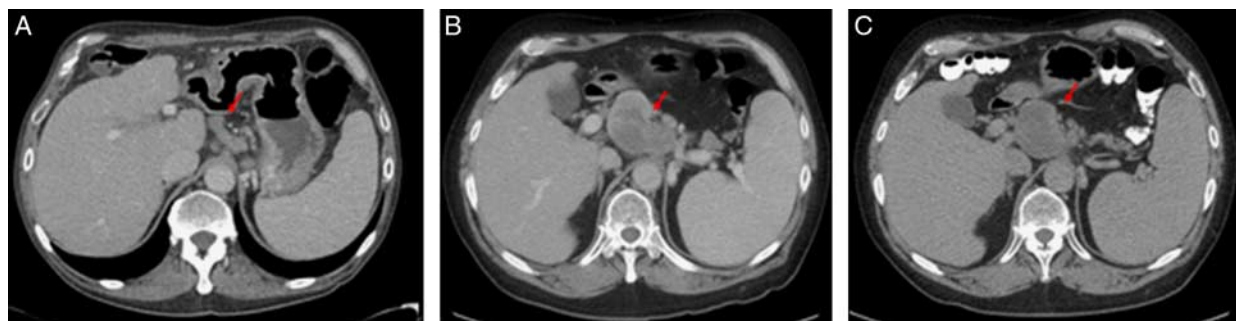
Case 3 CT scans over treatment course. A, Axial CT image demonstrates mildly enlarge gastrohepatic lymph node (red arrow) measuring 13 mm short axis on October 11, 2020, when the patient went to hospice. B, Axial CT demonstrated a significant increase in severity of lymphadenopathy after treatment lapse with the gastrohepatic lymph node short axis at 45 mm, with central hypoattenuation, possibly representing necrosis (red arrow). C, After 4 months of dual immunotherapy, the gastrohepatic lymphadenopathy seems similar or minimally decreased in size at 43 mm short axis. [full color online](#)
